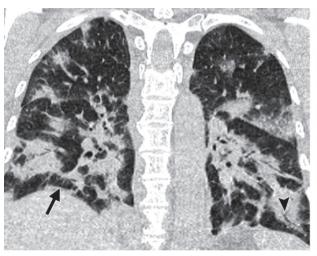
Organizing pneumonia in a 53-year-old woman who presented with fever and cough 5 months after allogeneic HSCT. BAL findings ruled out infection. (a) Coronal HRCT image shows patchy bilateral peribronchial and peripheral consolidation. Mildly dilated bronchi are seen in some of the areas of consolidation (arrowhead). Note the elongated perilobular consolidation in the right lower lobe (arrow). (b) Coronal HRCT image obtained 2 months after high-dose corticosteroid therapy shows complete resolution of the airspace disease.
